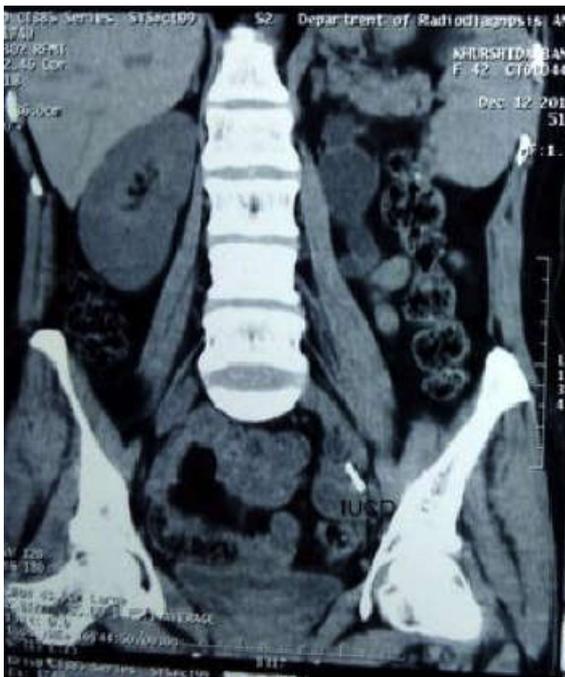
CT scan showing IUCD migrated into peritoneal cavity
